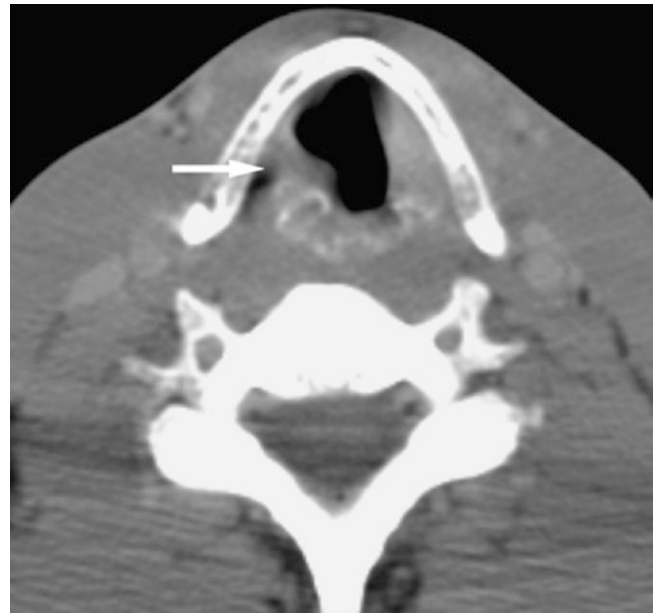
Right vocal cord paralysis secondary to lung cancer; 63-year-old man presents with hoarseness. Axial CT image through larynx shows right vocal cord (*arrow*) laterally in larynx
